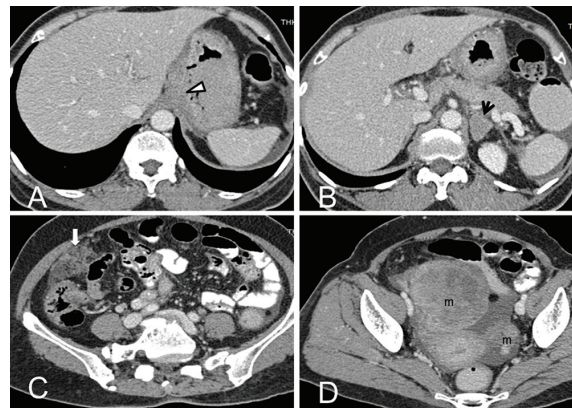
Axial CT scan of malignant cancer of stomach at cardia (white arrow head in A) shows left adrenal metastasis (black arrow in B), omental mass at right side abdomen (white arrow in C) and bilateral ovarian metastasis (m in D). Minimal ascites is observed at perisplenic, left paracolic gutter and pelvic cavity.
